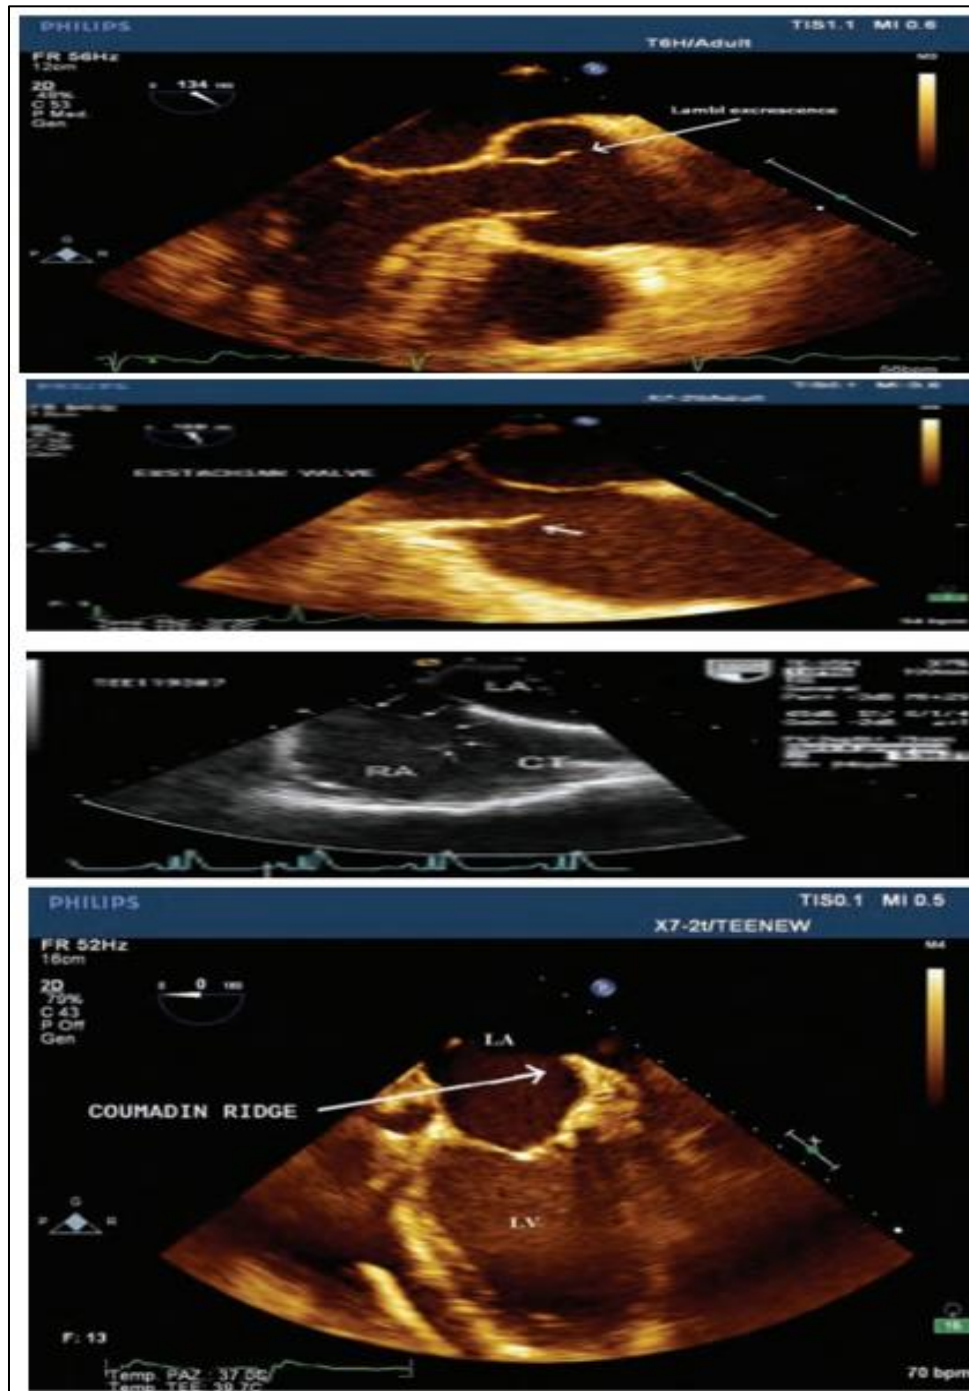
Artefacts images in Transesophageal Echocardiography.
